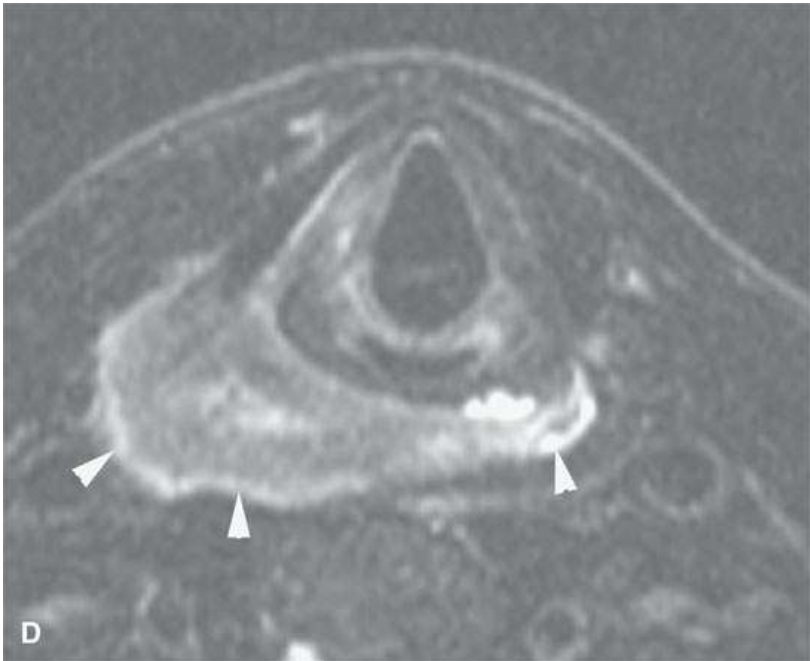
General trends of contrast enhancement of squamous cell carcinoma (SCCA) and malignancies in general as seen on magnetic resonance imaging in a pyriform SCCA (aA—dD) and tongue base SCCA (eE—gG). A: Non-contrast-enhanced T1-weighted (T1W) image shows poor tumor to muscle contrast. B: Contrast-enhanced T1W image shows enhancing tumor (*arrows*) contrasts well with muscle (*arrowheads*). C: T2-weighted (T2W) image shows fairly good tumor (*arrows*) to muscle (*arrowhead*) contrast. D: Fat-suppressed T2W image improves on the contrast seen in (cC) and shows peritumoral edema better (*arrowheads*). E: Contrast-enhanced fat-suppressed T1W image shows excellent tumor to muscle contrast but relative poor contrast with normal lymphoid tissue (*arrows*). F: T2W image shows good tumor to muscle contrast but relatively poor contrast with normal lymphoid tissue (*arrow*). G: Contrast-enhanced computed tomography for comparison with (e E) and (fF).
